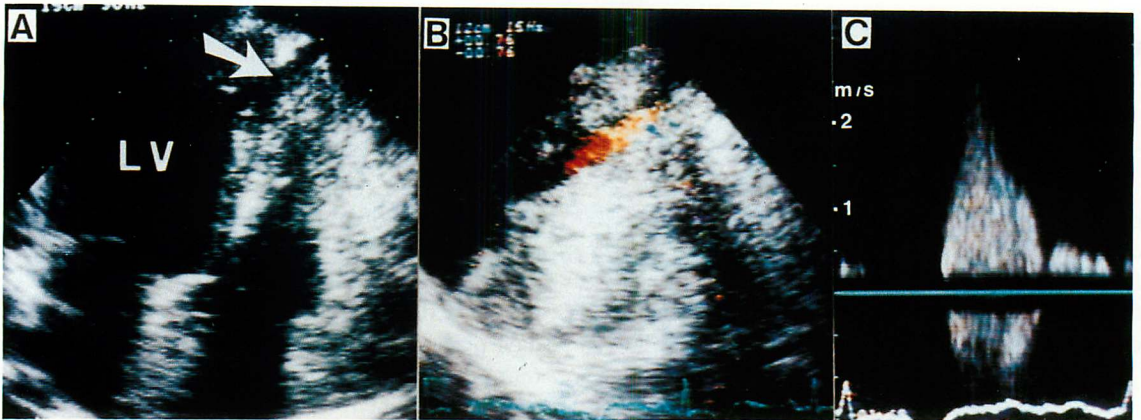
Two-dimensional and Doppler echocardiograms of right ventricular perforation and an interventricular septal defect.
